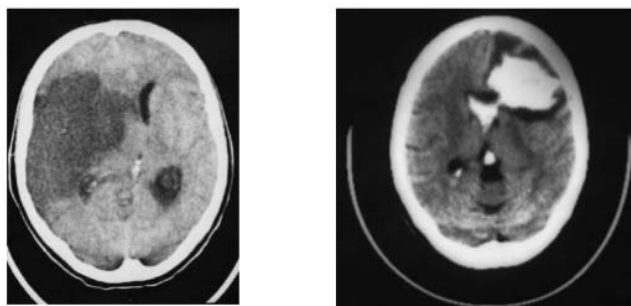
Computed tomography scan of two type of stroke: in the right part a ischemia stroke and in the left part hemorrhagic stroke [5].
